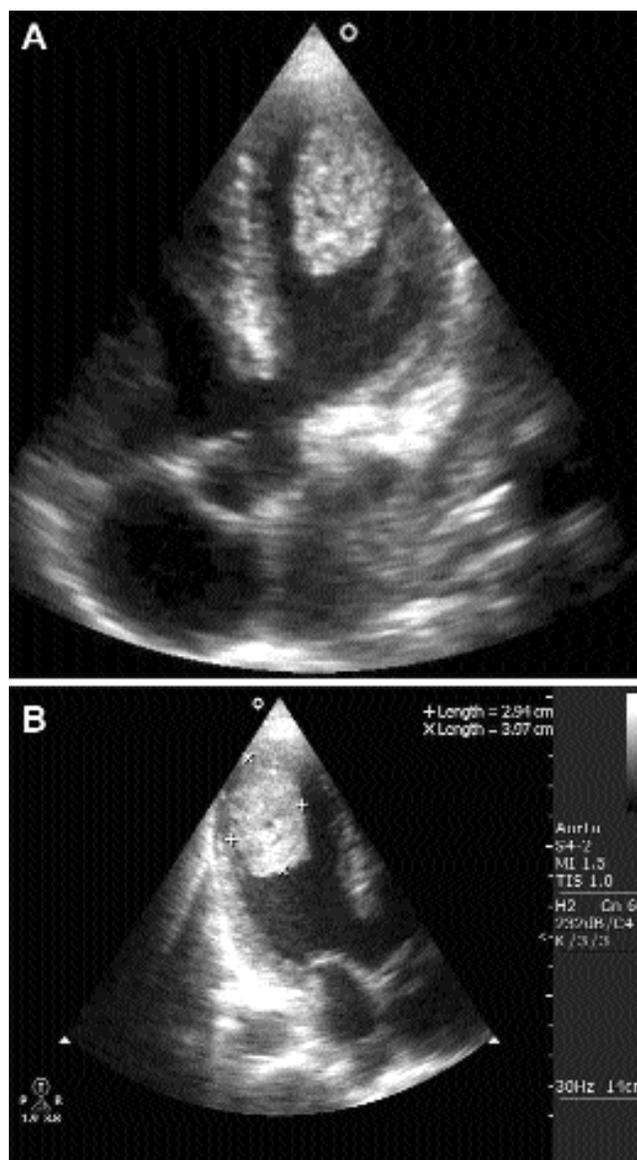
Transthoracic echocardiogram in four chamber view showing a membranous ventricular septal defect, overriding aorta and thrombus in the apical portion of ventricle (A). Thrombus sized 4.0 x 3.0 cm in the apical portion of left ventricle (B).
